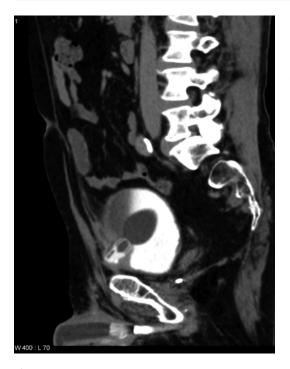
MRI image demonstrating reservoir erosion into the bladder (Published with kind permission of © Joshua P. Langston, 2016. All Rights Reserved)
